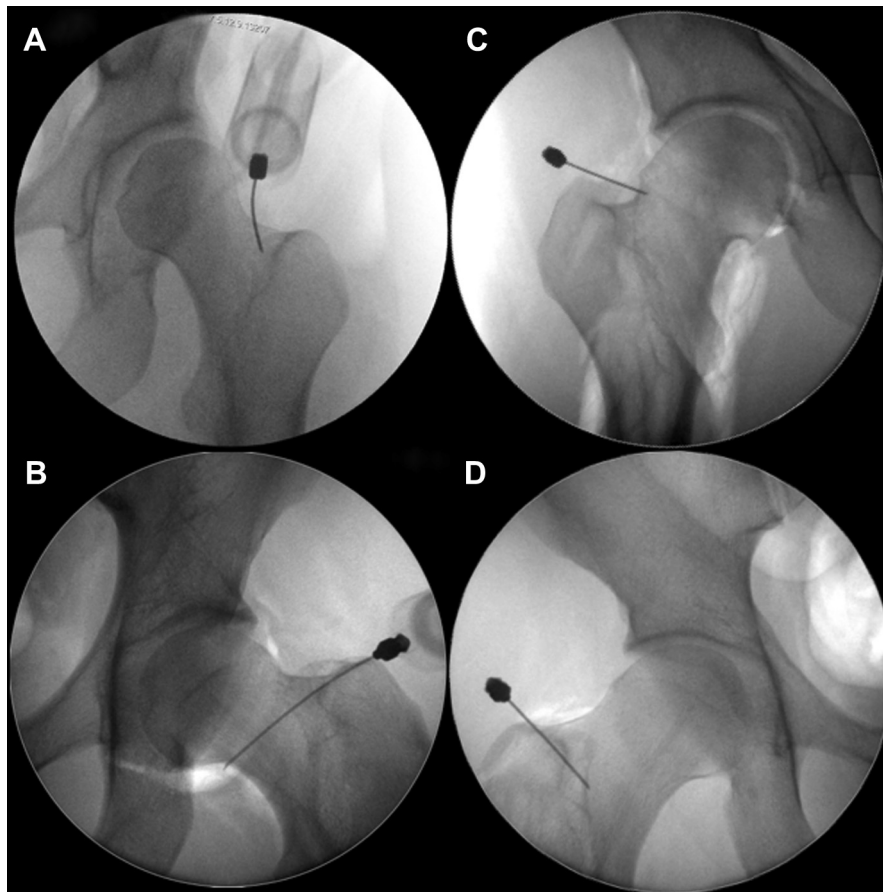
Four scenarios in which the needle was considered out of the joint and the respective reasons. These cases stress how important it is to assess the anteroposterior hip and pelvic radiographs of the patient before one uses this technique so that modifications can be made to the needle entry point in relation to the landmarks. (A) The patient has coxa valga with a short (medial to lateral) and thin femoral neck, as well as increased anteversion. Because of anteversion, the needle had to travel farther before coming in contact with bone and ended up too lateral. After contacting bone, the needle may slide farther laterally because of anteversion. This patient had increased BMI, and the landmarks were hard to appreciate. (B) The needle entered at a steep angle and came into contact with the bone, and air was introduced. During injection of air, the needle slid down the neck, because it was positioned on top of the “ridge line” and the pressure of the air propelled it off the bone and down the neck. (C) A patient with a relatively short articular trochanteric distance and a large cam lesion. The needle was positioned in the joint but was placed into the cam lesion’s soft bone and fibrocartilage and resulted in backflow of air out of the joint (in addition to producing an arthrogram). In this patient an anteroposterior pelvic radiograph evaluation was (unintentionally) not made before needle placement. (D) Image of patient from Fig 5A with lateral ASIS variation. This resulted in positioning of the needle too lateral and outside of the joint.
